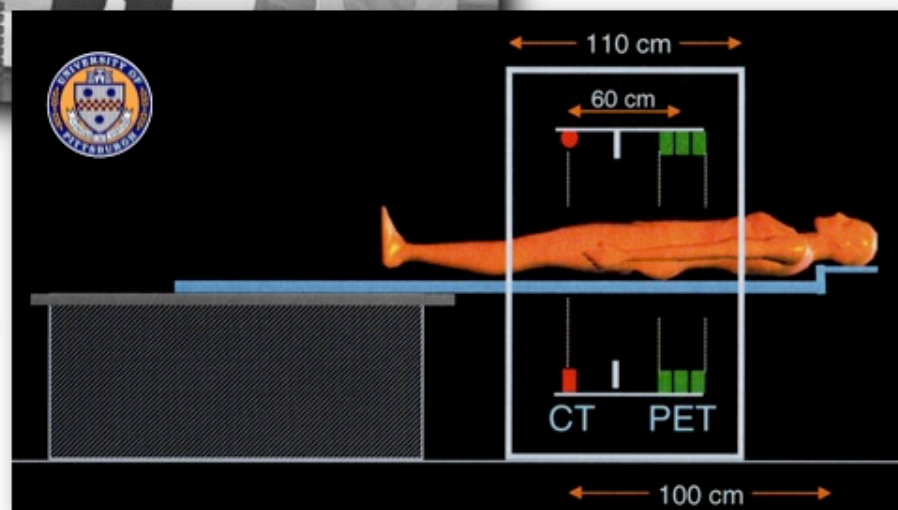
Outline of proposed PET/CT scanner.
